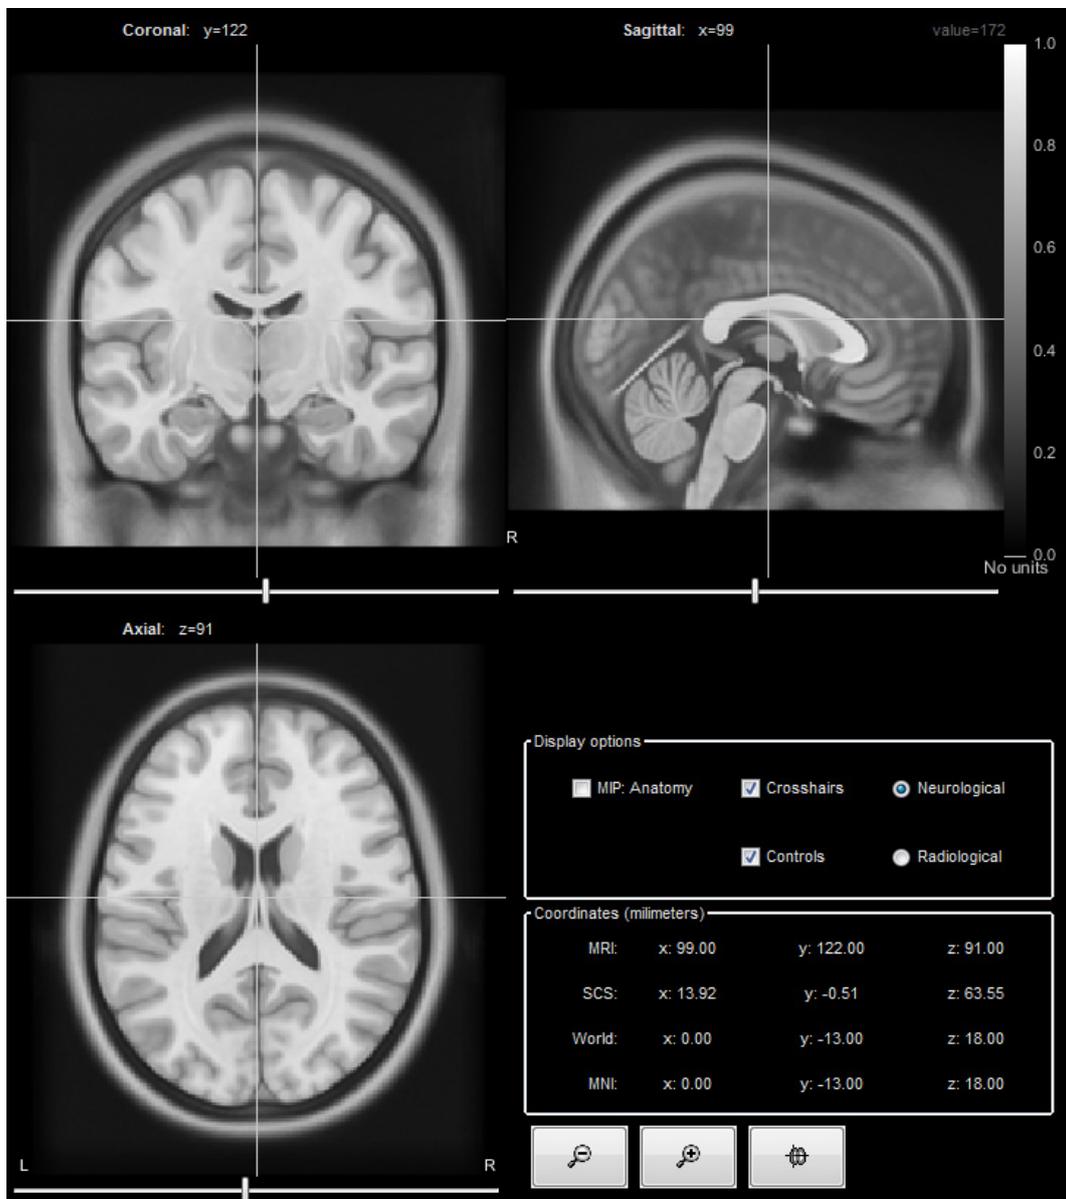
MRI Image in Three Different Sections for Proper Processing.
